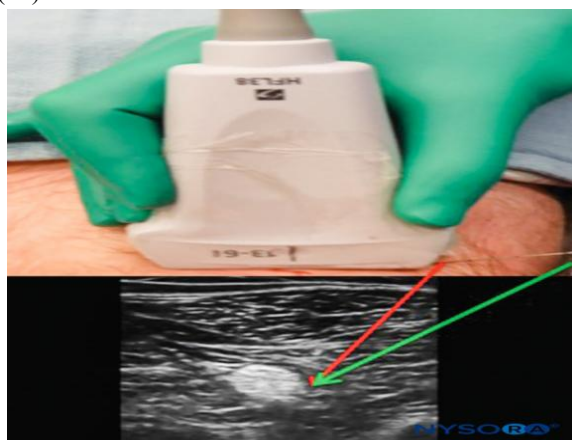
If you place the needle just next to the ultrasound probe, you could have trouble seeing. Although the needle must go through more tissue, it can be better seen (green arrow) and the echo response is greater when inserted at a distance from the probe, which allows for a more superficial method (14)
